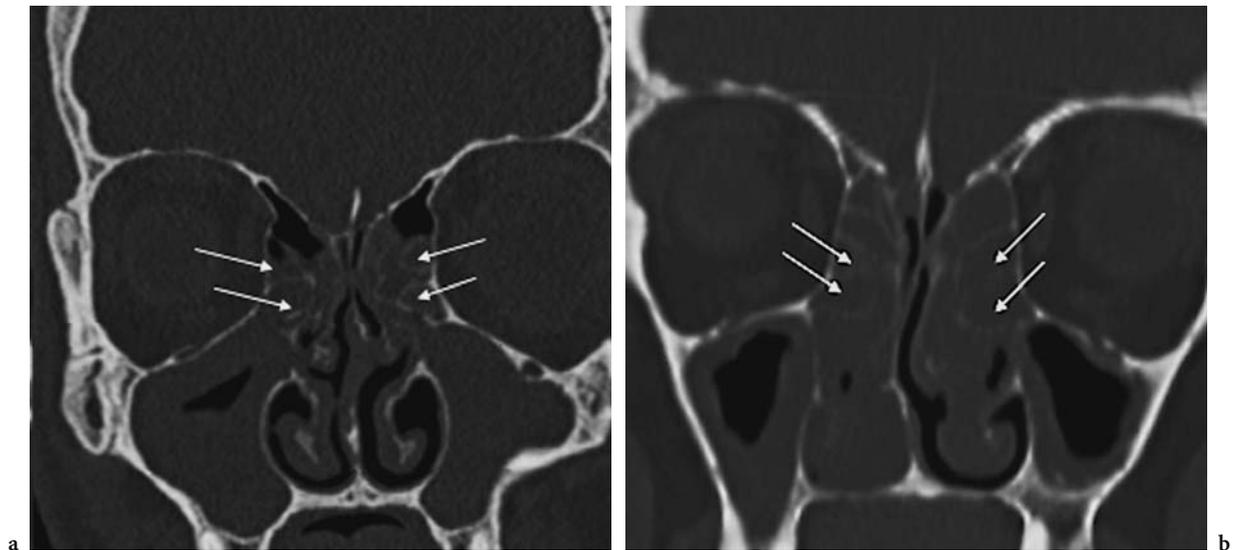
In cases of extensive sinus disease it is difficult to evaluate the integrity of the fine bony (ethmoid) septa (arrows), especially at low-dose CT. This can be due to bony erosion, partial volume effect or lack of contrast at low dose. a Coronal 2 mm image of a low-dose 16-MDCT (same scan protocol as in Fig. 9.5) with effective dose of 0.12 mSv in a 56-year-old man; b comparable extensive sinus pathology in a 36-year old man at standard-dose 16-MDCT with 120 kV, 100 mAs, (CTDI_{vol} of 21.4 mGy) and effective dose of 0.55 mSv, with bony erosion of the ethmoid septa (arrows)
